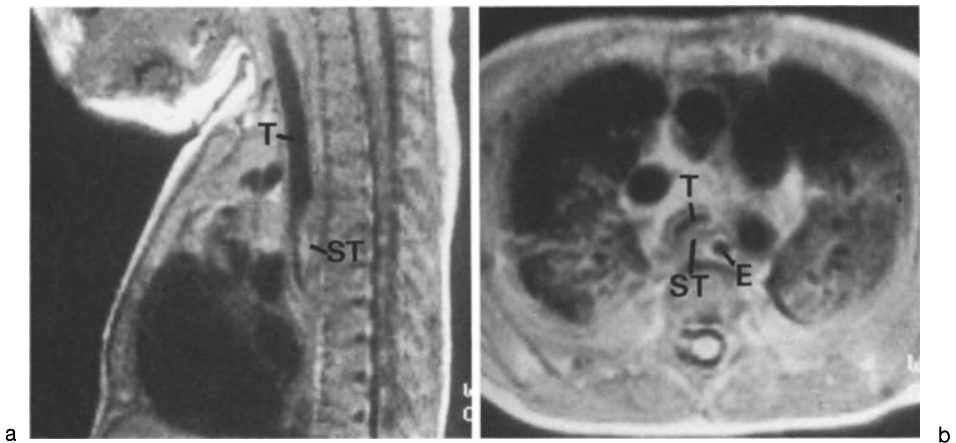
Case 4: tracheal narrowing by scar tissue after repair of oesophageal atresia. In MRI neither in sagittal (b) nor in transaxial (c) slices is there a vascular cause for the distal tracheal stenosis. On a sagittal view the impression from dorsal is shown. The transaxial plane demonstrates the tracheal (*T*) narrowing from dorsal and the location of the oesophagus (*E*). Between the trachea and oesophagus additional tissue (*ST*) after repair of the oesophageal atresia is found (scar tissue)
